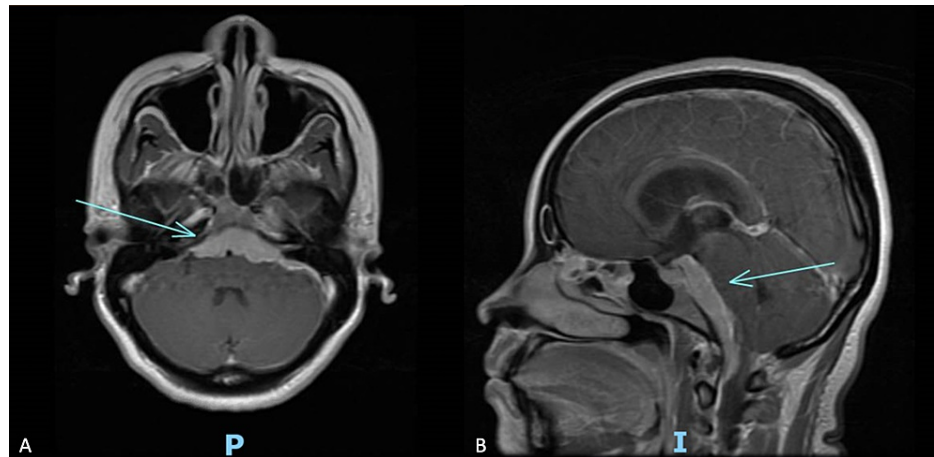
Pre-treatment brain MRI with contrast in axial (A) and sagittal (B) views demonstrate bulky enhancing tumor ventral to the pons at the skull base.
